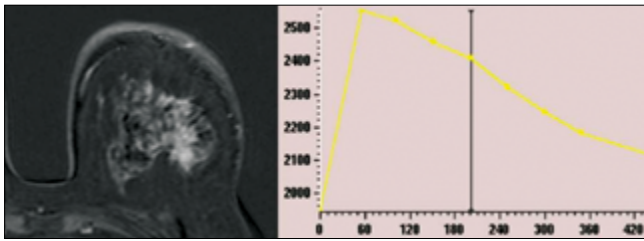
Pharmacokinetic curve of pre-treatment dynamic contrast-enhanced MRI of Case 2 before treatment. A 5x6 cm, diffusely growing mass mainly located in the middle and outer quadrant of the left breast, radiating from the lower to the upper quadrant was evaluated as BIRADS-5. The left breast skin is thick in appearance
